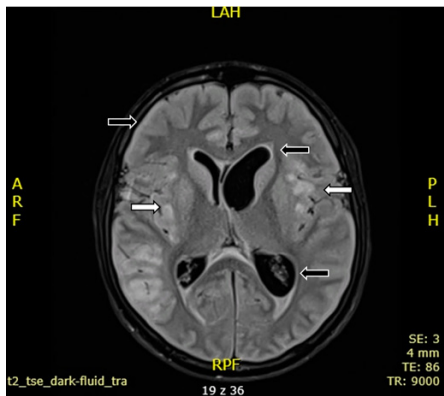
MRI scan on the 9th day of hospitalization. White arrows indicate the presence of subcortical diffusion, which is shown in black. Detailed information regarding brain symptoms is provided, including flattened cerebral sulci and lateral ventricle enlargement
